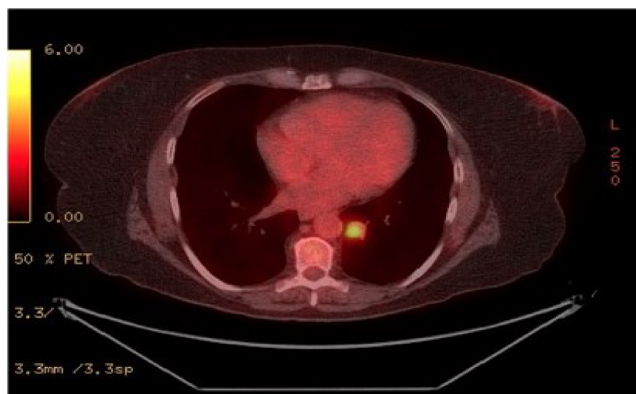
PET scan reveals area of high standardized uptake value (SUV) lateral to the descending aorta. Area of uptake coincides with known left lower lobe nodule from prior CT.
